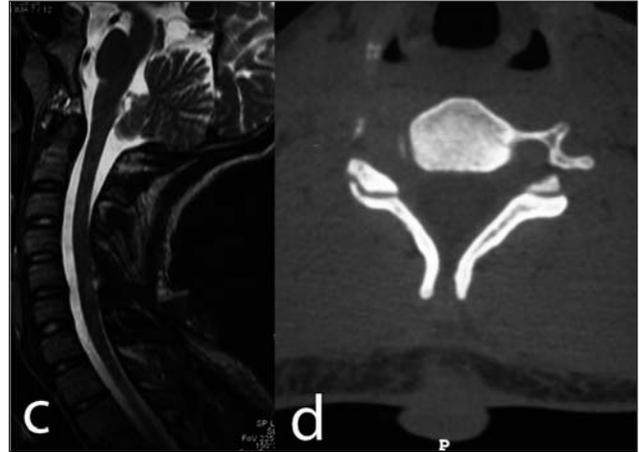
T2- weighted cervical MRI in hyperextension. (D) CT scan of the adult case showing the spina bifida at the level of C5.
